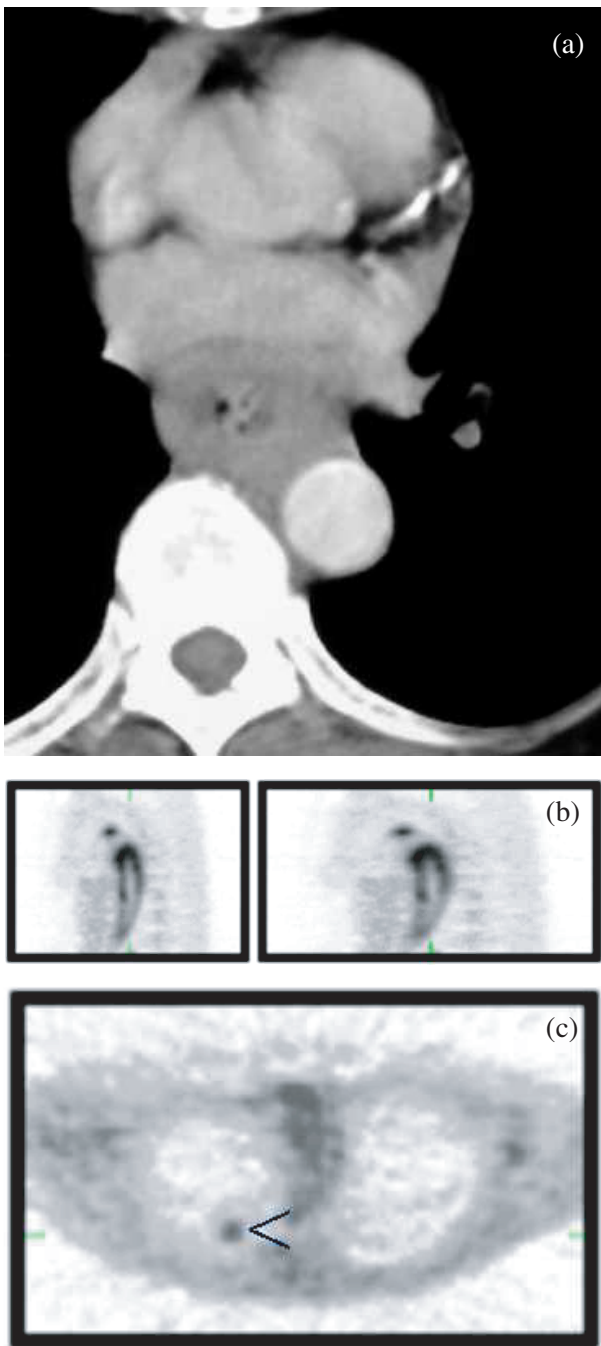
(a) CT scan of patient with oesophageal cancer showing infiltration into the mediastinum with aortic invasion (T4 tumour). (b) PET scan of the same patient showing oesophageal uptake but the extent of mediastinal invasion is not clearly identified. (c) PET scan of the same patient with uptake in lung metastasis (arrow) not seen on the CT.
